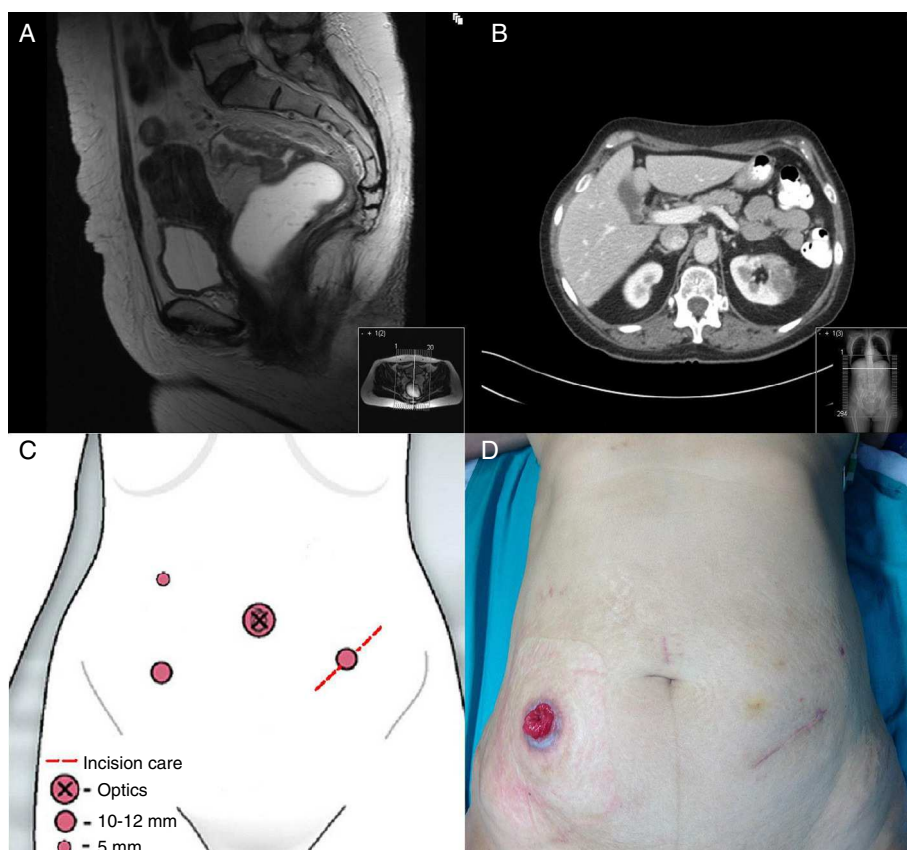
(A) Pelvic MRI demonstrating rectal mass that does not surpass the muscularis propria; (B) axial CT scan of the abdomen showing a left renal mass measuring 5 cm; (C) trocar placement used for nephrectomy and lower anterior resection; (D) image of the abdomen of the patient with protective ileostomy.
